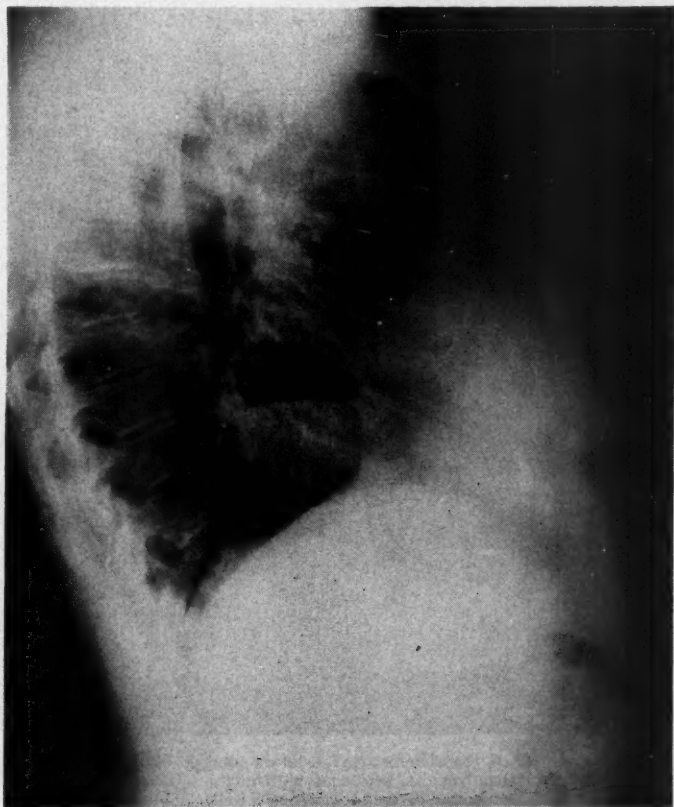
Left lateral projection of the chest roentgenogram made in 1953. Moderately large hiatus hernia with an air-fluid level is seen.
